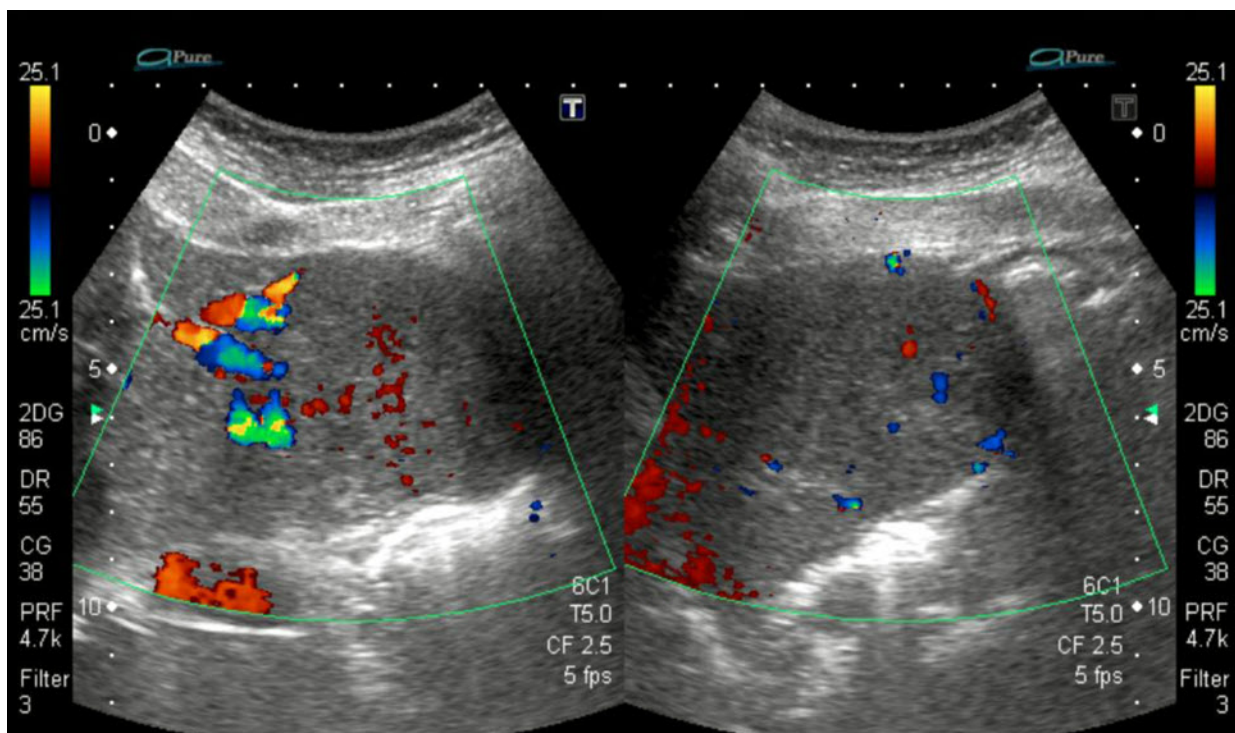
(Top) Ultrasound of the abdomen showing a well defined hypoechoic lesion in the left lobe of the liver; (Bottom) Doppler study showing enhanced flow over lesion in left hepatic lobe
